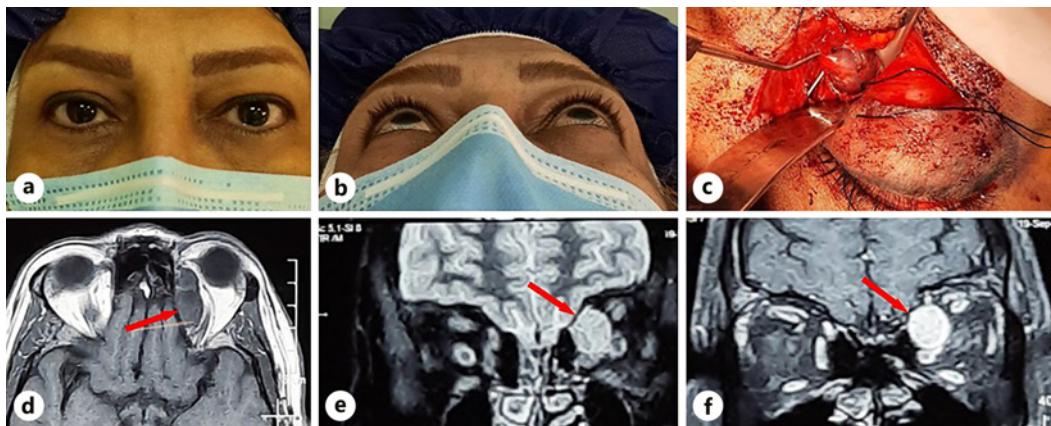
External photo demonstrating proptosis and fullness in the superonasal aspect of the left orbit from the front view (a) and worm's eye view (b). Intraoperative photo demonstrating superior oblique (SO) muscle with a mass (c), T1-weighted magnetic resonance imaging without fat suppression, axial view demonstrating enlarged SO muscle (d), T2-weighted image, and post-contrast T1-weighted image, coronal view revealing a mass within the SO with contrast enhancement (e, f) pushing medial rectus muscle to the inferior. Red arrows demonstrate the SO in MRI images.
